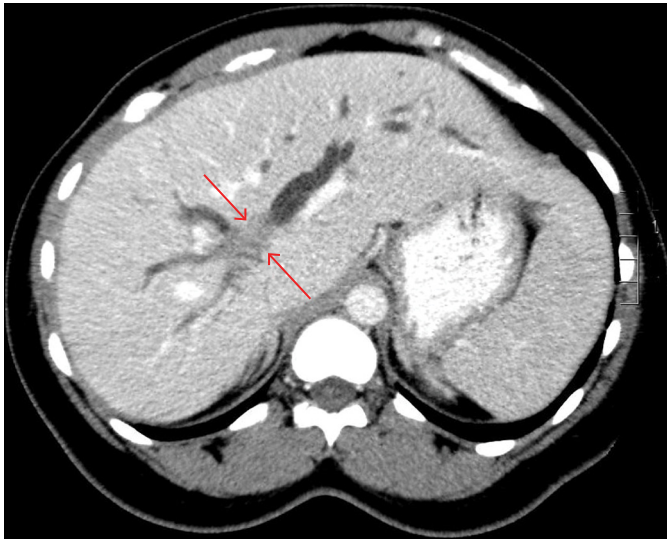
CT image demonstrating an ill-defined, infiltrative mass at the confluence of the right and left hepatic ducts (arrows).
